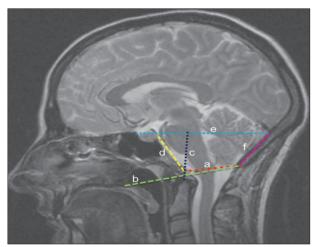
A MR imaging of McRae line (a), Chamberlain line (b), Klaus index (c), clivus length (d), Twining line (e), and length of supraocciput line (f).
